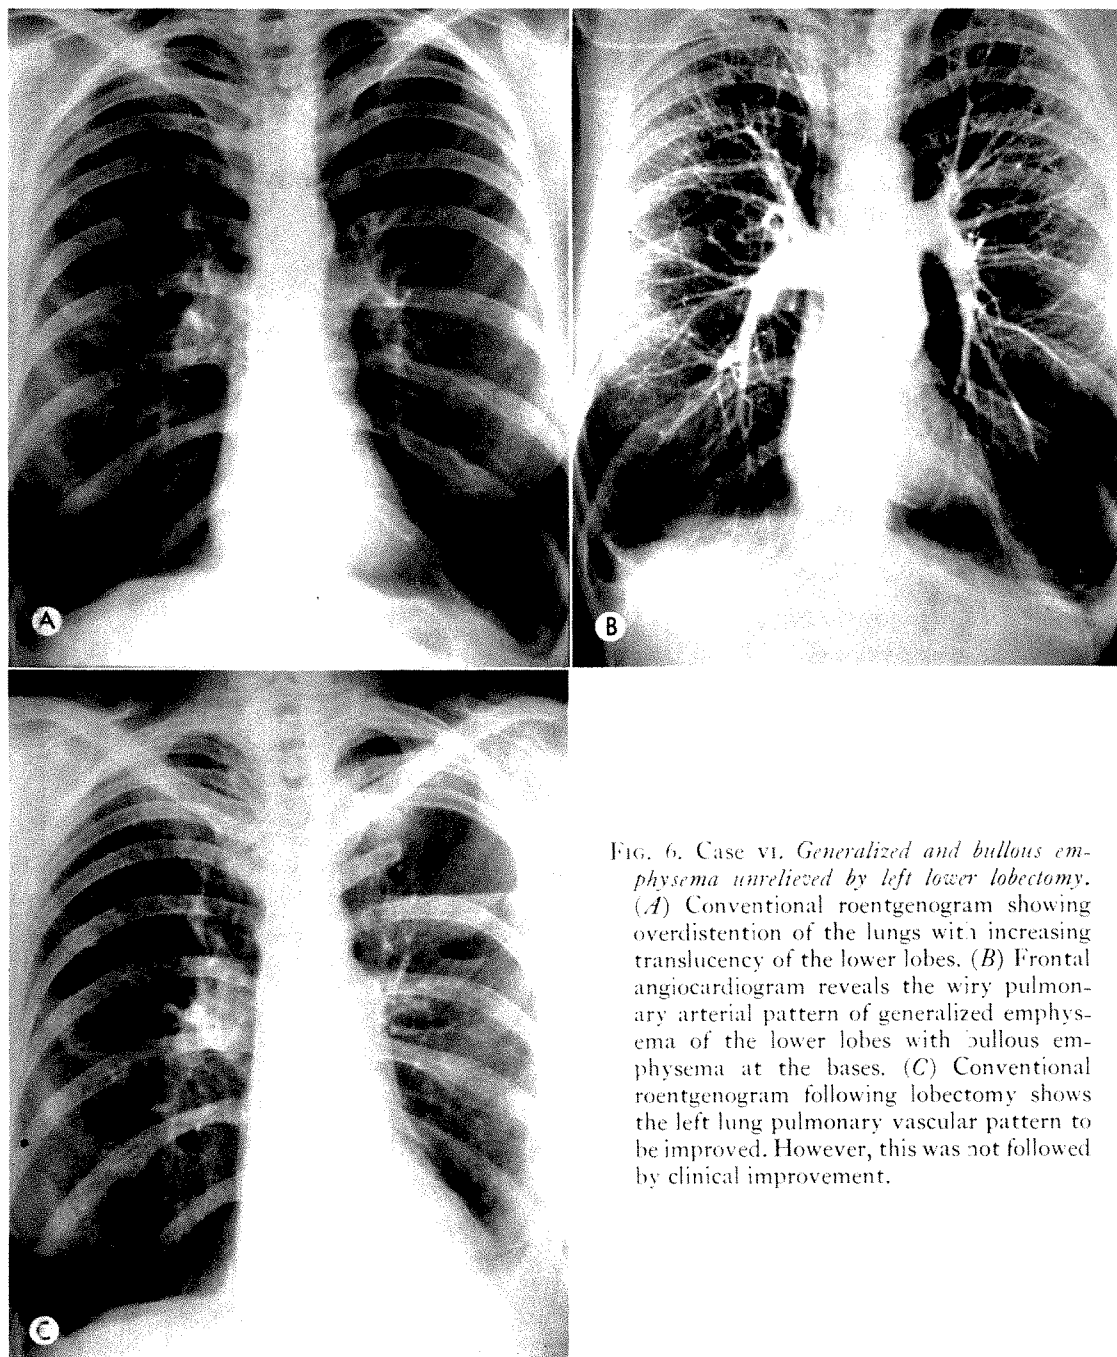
Case VI. *Generalized and bullous emphysema unrelieved by left lower lobectomy.* (A) Conventional roentgenogram showing overdistention of the lungs with increasing translucency of the lower lobes. (B) Frontal angiocardiogram reveals the wiry pulmonary arterial pattern of generalized emphysema of the lower lobes with bullous emphysema at the bases. (C) Conventional roentgenogram following lobectomy shows the left lung pulmonary vascular pattern to be improved. However, this was not followed by clinical improvement.
